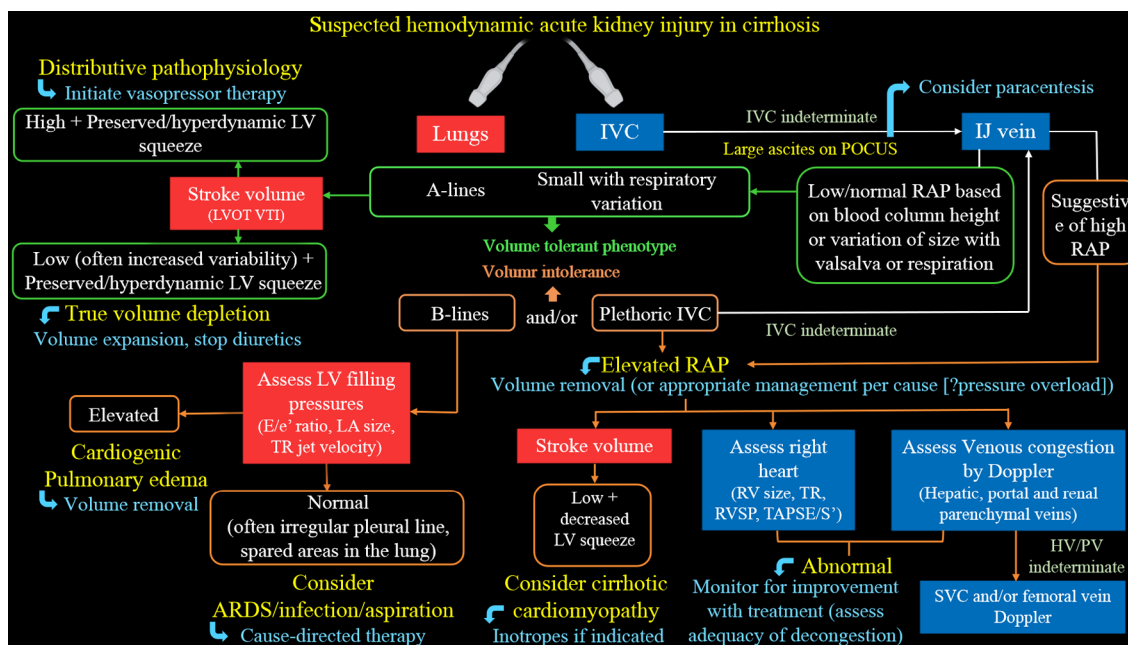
Proposed diagnostic algorithm for approaching acute kidney injury in a patient with cirrhosis. Citation: Koratala A, Reisinger N. Point of Care Ultrasound in Cirrhosis-Associated Acute Kidney Injury: Beyond Inferior Vena Cava. *Kidney360* 2022; 3: 1965-1968. Copyright© 2022 by the American Society of Nephrology (corresponding author's prior open access publication).
